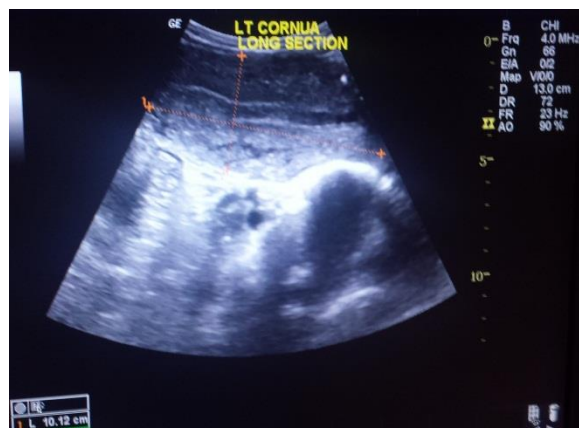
Ultrasound showing the left cornua on longitudinal section.
